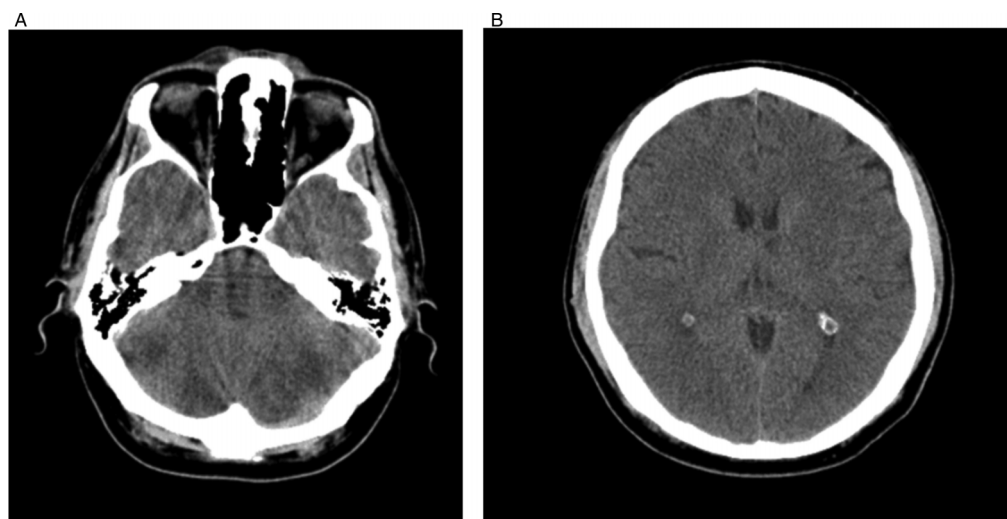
(A and B) Hypodense area concordant with infarct in bilateral cerebellar area distinct on the left side (A) and in thalamus on the left side in CT scan.
